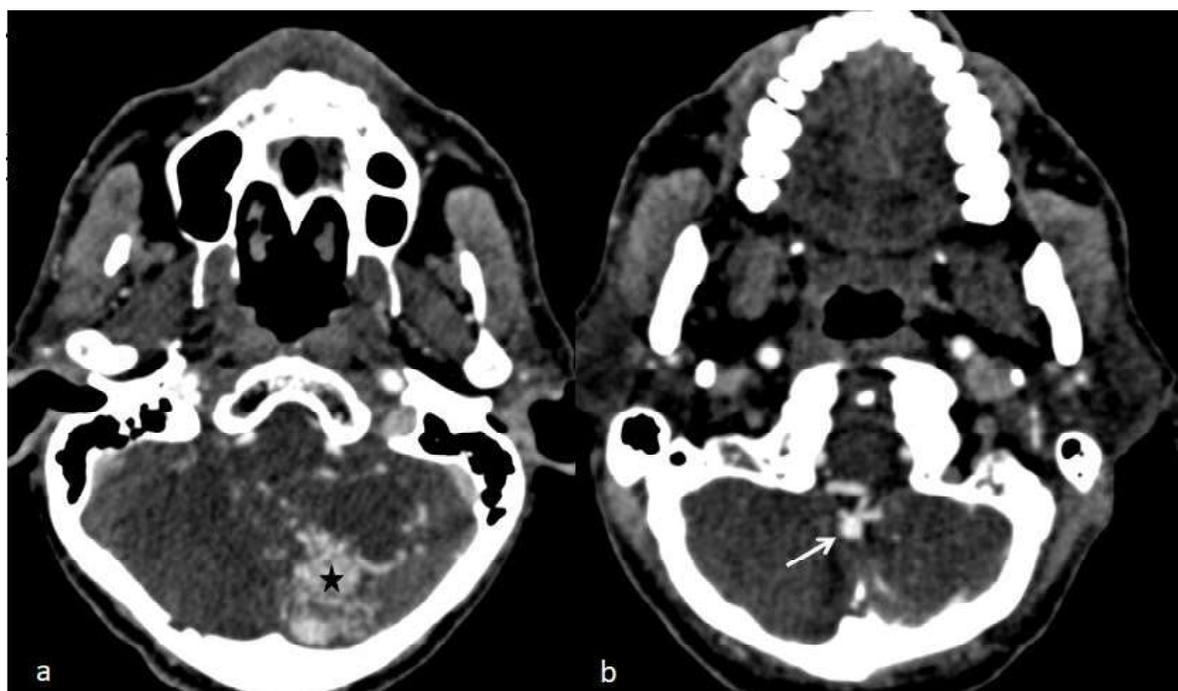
(a,b): Preoperative CT Angiography axial images showing AVM with nidus (asterisk) in left cerebellum with presence of flow related pseudoaneurysm (white arrow).
